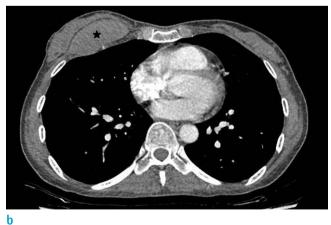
(a, b) Chest CT with contrast enhancement showing a well-defined oval shaped mass in the right chest wall. The density of the mass was measured as 60-70 HU on both pre-contrast image (a) and contrast-enhanced image (b). There was no contrast enhancement or change in HU.
